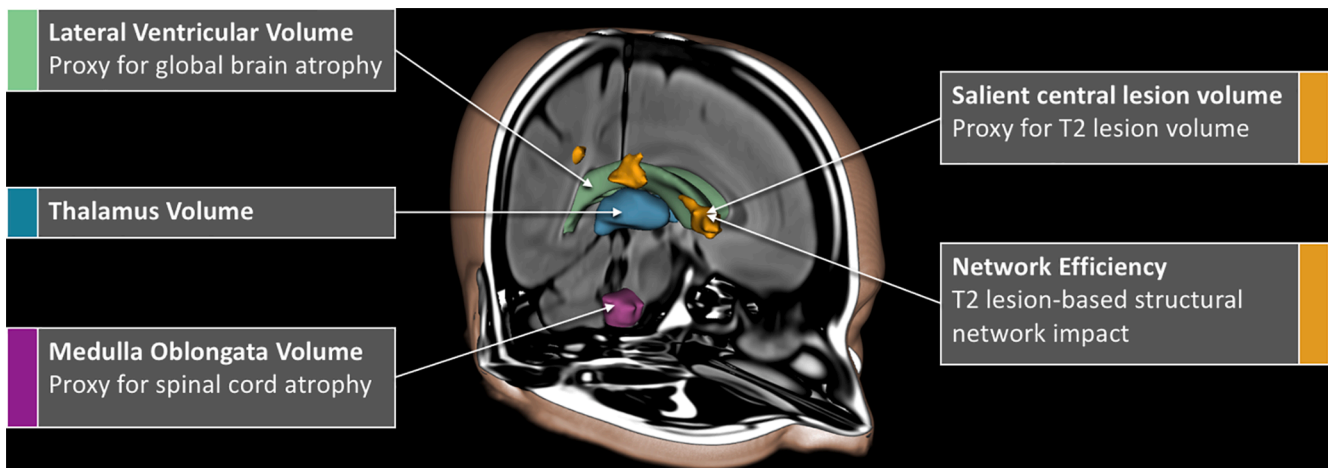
T2-FLAIR image processing. Automated methods of measuring LVV, SCLV, MOV, thalamus volume, and network efficiency from clinical quality T2-FLAIR images were applied. Abbreviations: T2-FLAIR, T2-weighted fluid attenuated inversion recovery; LVV, lateral ventricular volume; SCLV, salient central lesion volume; MOV, medulla oblongata volume.
